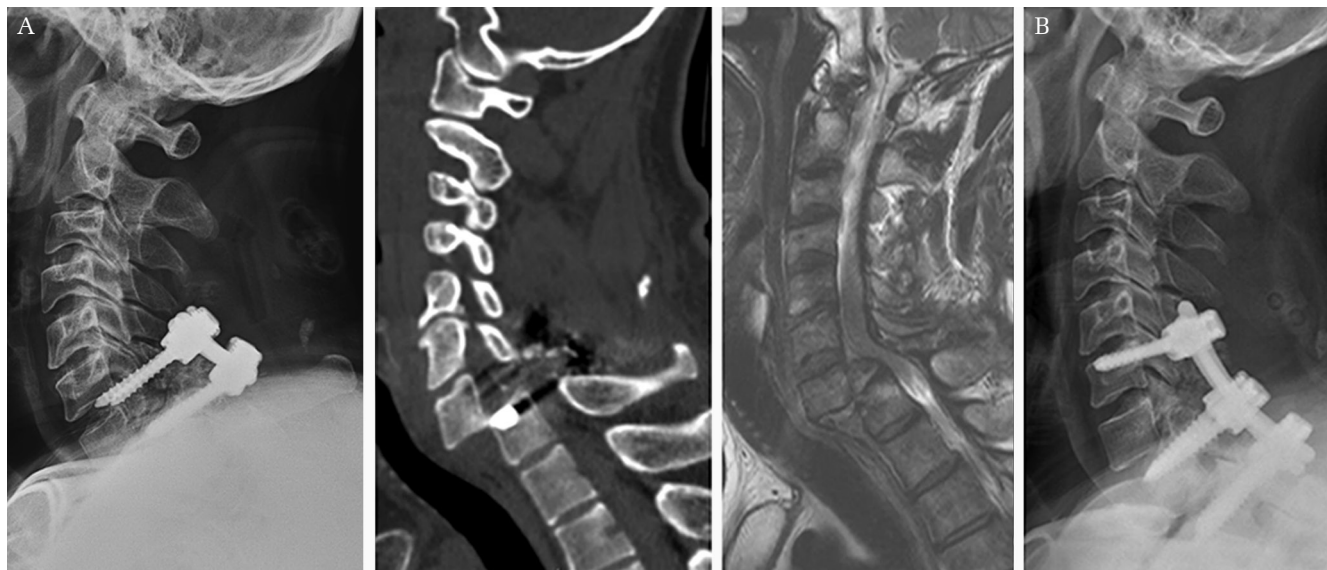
(A) Preoperative X-ray image, CT scan, and MRI showing spondyloptosis with the C7-T1 screw displacement that was previously inserted. (B) Postoperative X-ray showing good alignment.
